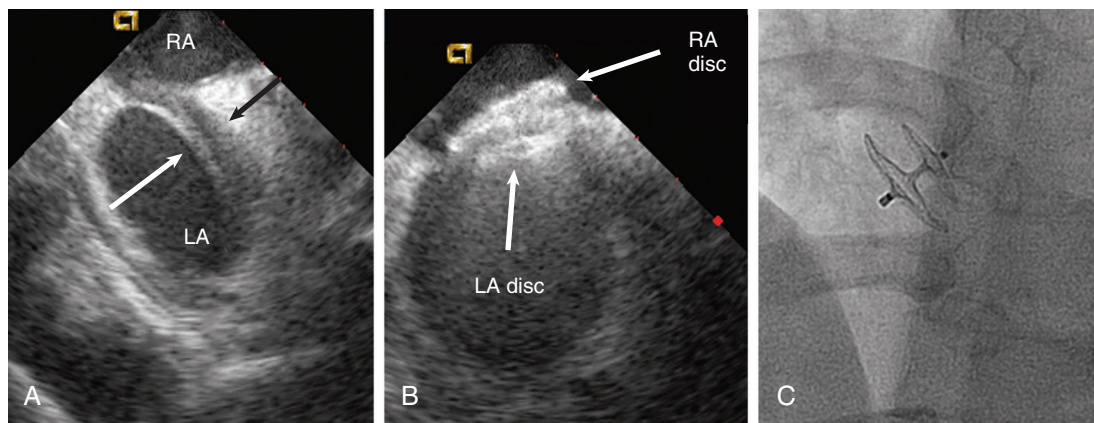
Intracardiac echocardiographic guidance of PFO closure in a subject participating in the RESPECT trial using the Amplatzer PFO occluder. A, The thin septum primum is held apart from the thick septum primum (arrows) by a guidewire. B, The deployed device functions as a cuff link holding the two tissue flaps together. C, A fluoroscopic image from a left anterior oblique cranial projection shows the deployed device placed properly. LA = left atrium; RA = right atrium.
